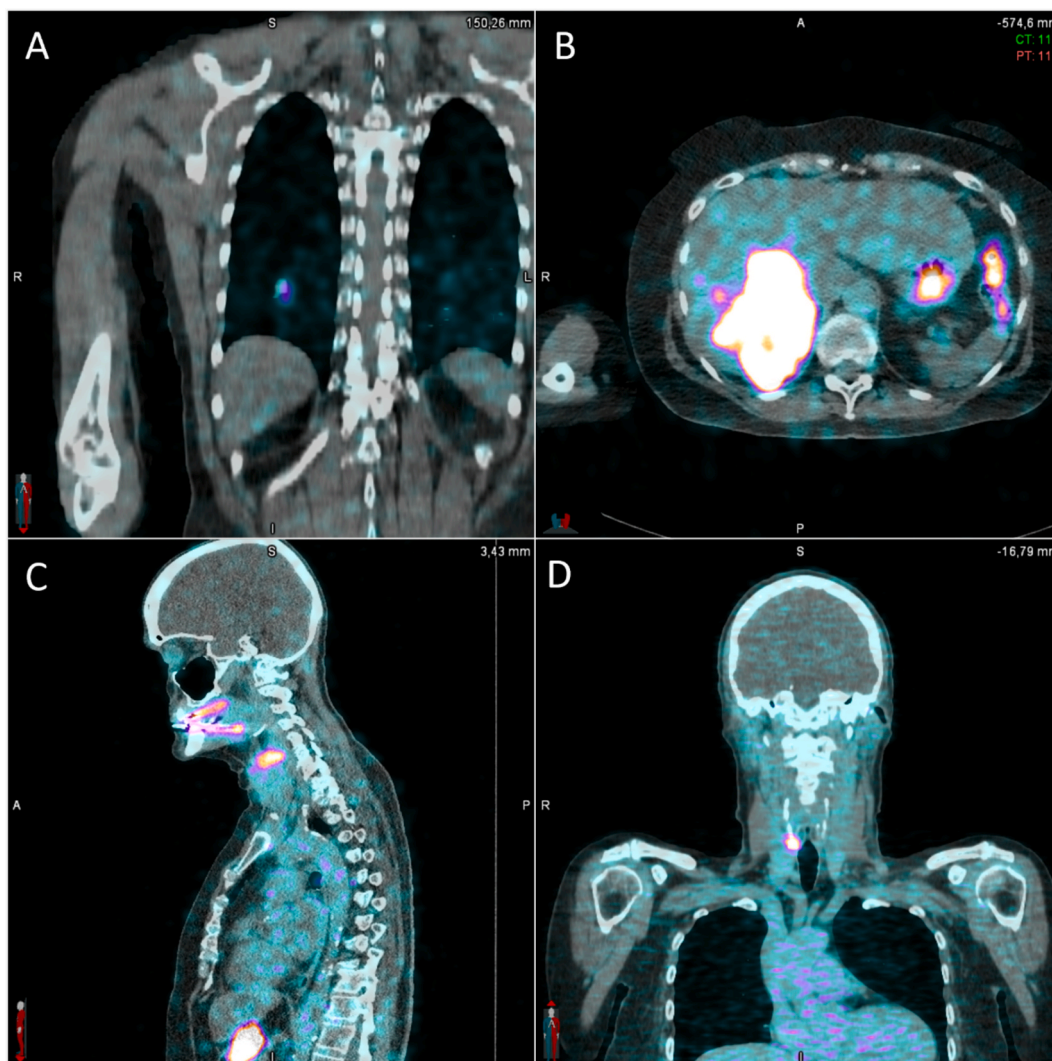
Baseline ^{124}I PET/CT scans performed 24 h after administration of 37 MBq ^{124}I of four different RAI-R DTC patients with ^{124}I -avid lesions. The window level was set to 0–1.5 kBq/mL (equaling a body-weighted SUV of approximately 0–4 g/mL) for each patient. (A) a pulmonary macrometastasis in the right lower lobe, (B) a large liver metastasis in the right liver lobe, (C) a local recurrence in the left thyroid bed, (D) a local recurrence in the right thyroid bed.
